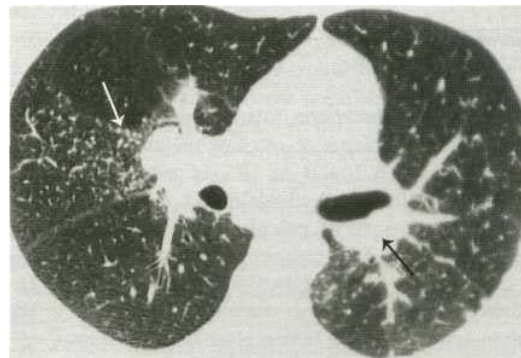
CT scan in sarcoidosis. Note enlarged glands at the hilum (black arrow) and nodular shadowing, particularly in right middle lobe (white arrow).
